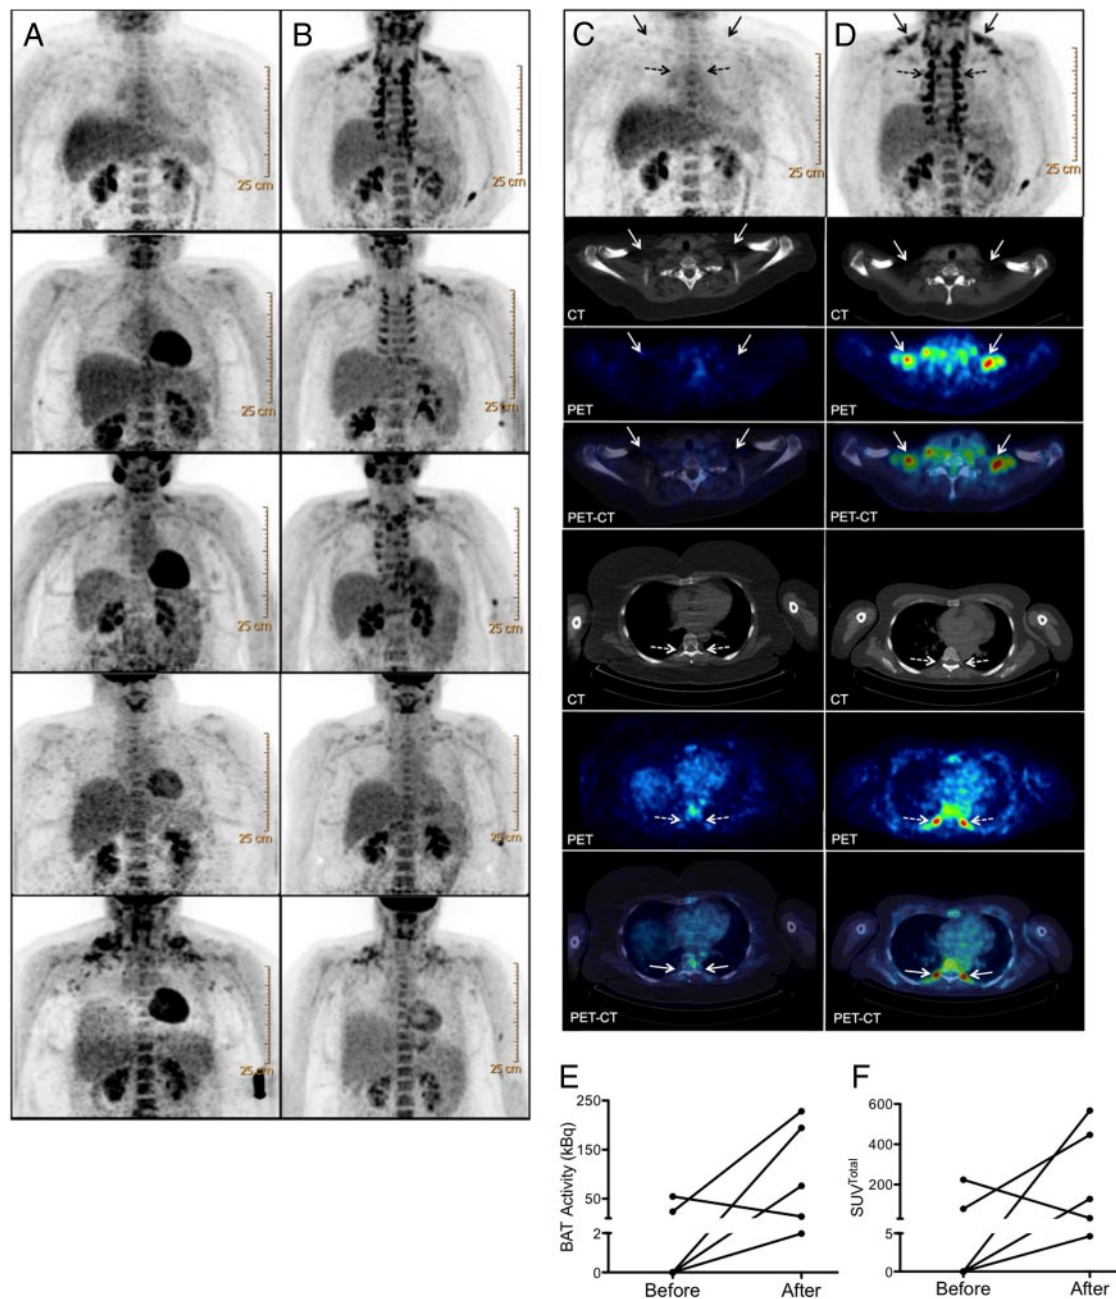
BAT activity before and after WL. A, PET images of five morbidly obese subjects before bariatric surgery (A) and after WL (B). C, PET image, CT image and PET-CT-fusion image of the subject who showed the largest increase in BAT activity before (C) and after WL (D). BAT activity was recruited in both supraclavicular and paravertebral areas, indicated by *solid* and *dashed arrows*, respectively. *Solid arrows* indicate bilateral supraclavicular regions in which BAT activity was observed after WL. *Dashed arrows* indicate bilateral paravertebral regions in which BAT activity was observed after WL. E, BAT activity in kilobequerels and total SUV (F) before and after WL for the five subjects depicted in A and B. Baseline characteristics of subjects shown are from a report published elsewhere (10).
